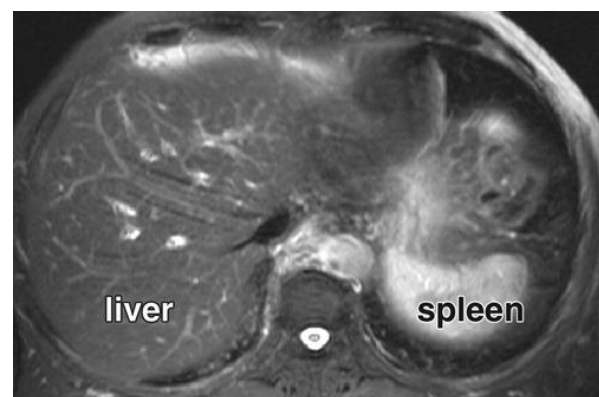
Typical MR imaging examination of the liver. (a) On an axial standard fat-suppressed T2-weighted MR image, the spleen is much brighter than the liver. This sequence is considered to be sensitive for the depiction of solid liver lesions, which typically follow the signal intensity of the spleen. (16)
